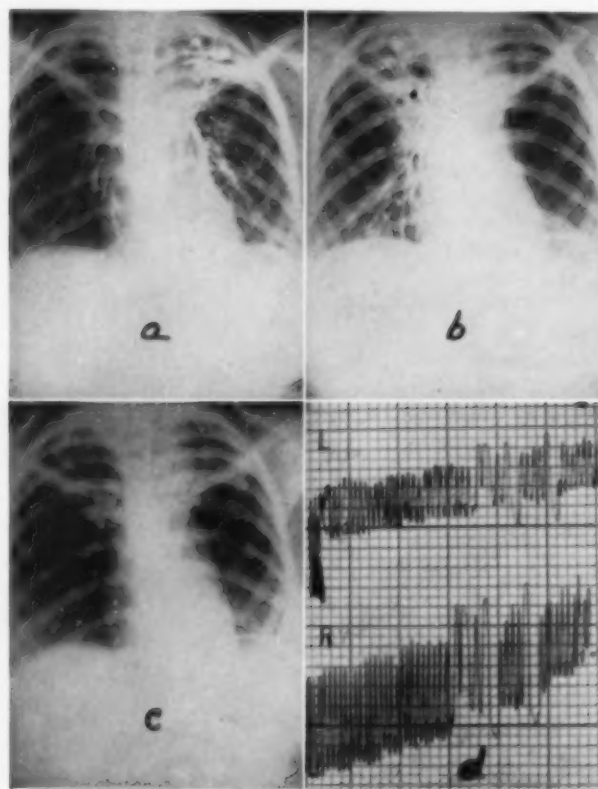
shows separate Ioduran B fillings of the left and right lungs. Both upper lobes have cavitary disease. Roentgenogram (c) of Fig. 4 taken 24 hours later shows no residual of the contrast medium. Chart (d) of Fig. 4 is a bronchspirometric tracing which indicates a considerable decrease in oxygen consumption, tidal volume, and vital capacity on the left (L) as compared to that of the right lung. The latter type of examination gives information about the loss of function of the more extensively involved left side. A paper on pulmonary function studies will be published later.
